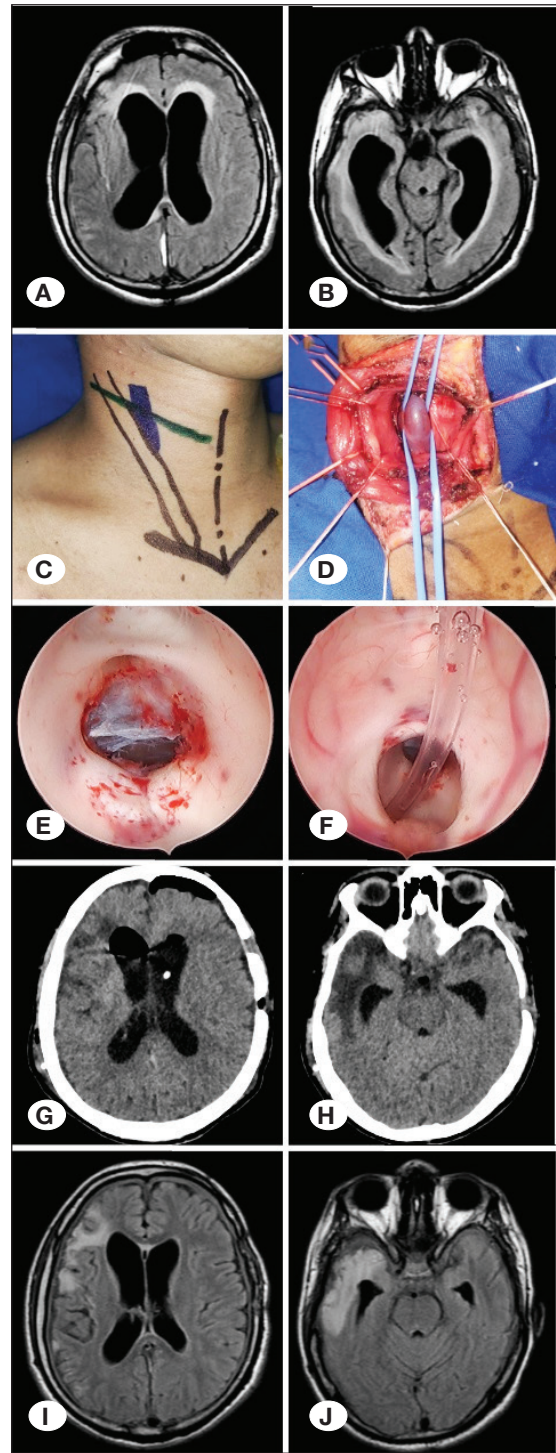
Case N°7. ETV with a ventriculoatrial valveless catheter. A, B) Preoperative MRI study. C, D) Internal jugular vein dissection. E, F) Intraoperative intraventricular endoscopic procedure. After the ETV was finished, a valveless ventriculoatrial catheter was inserted under direct endoscopic vision. G, H) Early postoperative CT scan. I, J) Postoperative MRI study at the six-month follow-up. The different protocols used for MRI acquisition are noted. The images highlight postoperative changes in the temporal horns of the lateral ventricles, which correlate with improved clinical outcomes.
